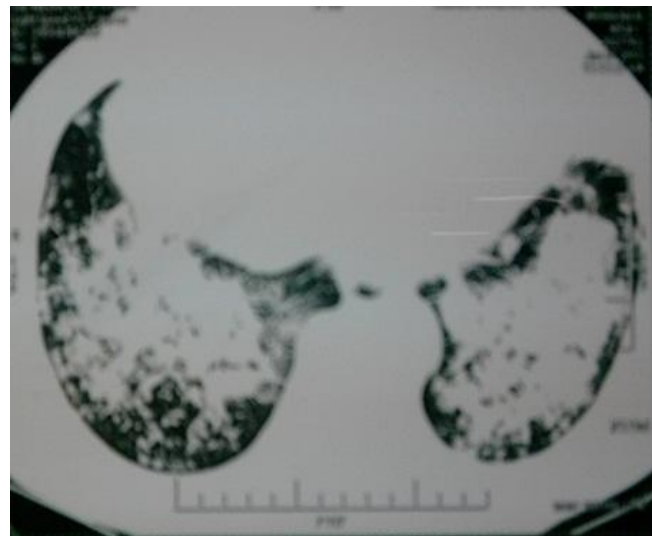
HRCT Thorax Showing Bilateral Lower Lobe Pneumonitis
